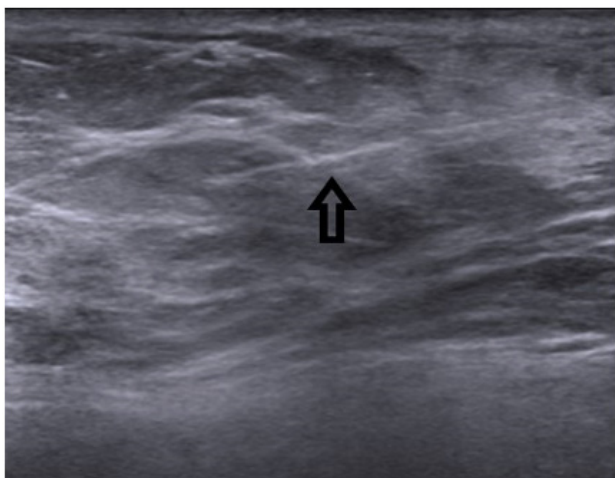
Ultrasound image shows echogenic biopsy needle (black arrow).
